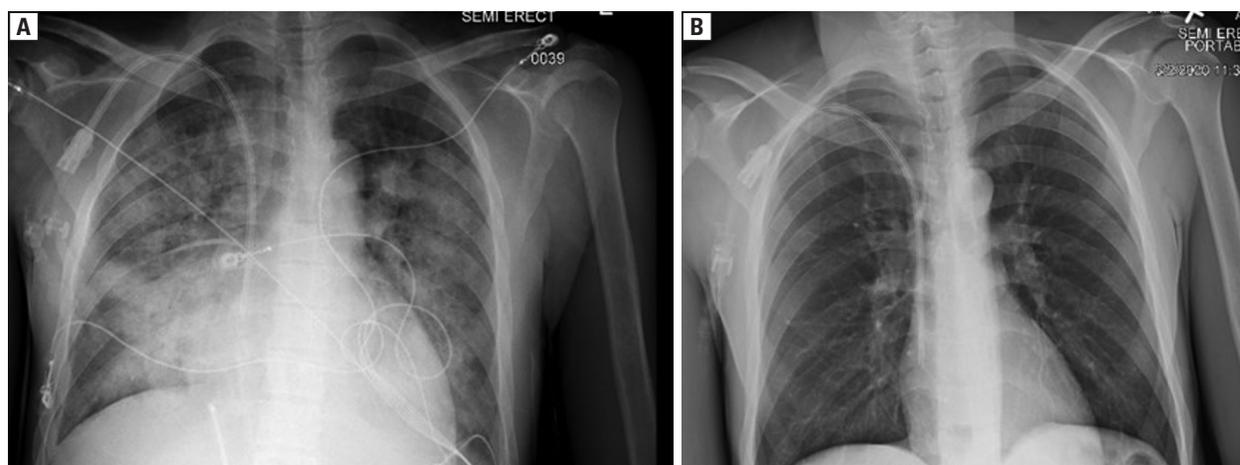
Chest radiograph of a patient during a severe attack of acute chest syndrome (A) and after resolution of the episode (B)
